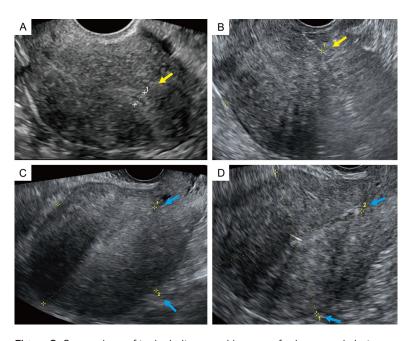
Comparison of typical ultrasound images of adenomyosis between the two groups. Arrows indicate the location of the lesions. A: Mirena group before treatment; B: Mirena group after treatment; C: Mirena combined with Leuprorelin group before treatment; D: Mirena combined with Leuprorelin group after treatment.
